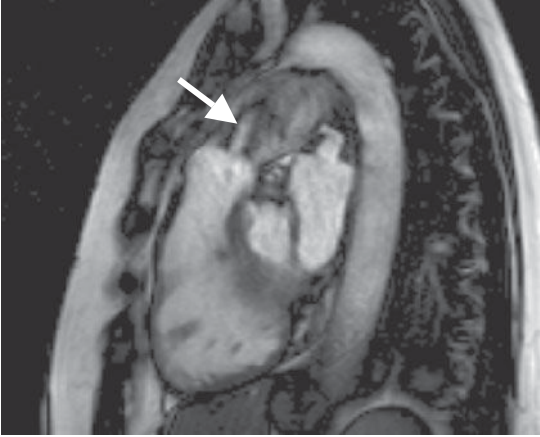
Cardiac magnetic resonance image showing the RV outflow tract. There is significant PS (arrow indicates high velocity jet).
